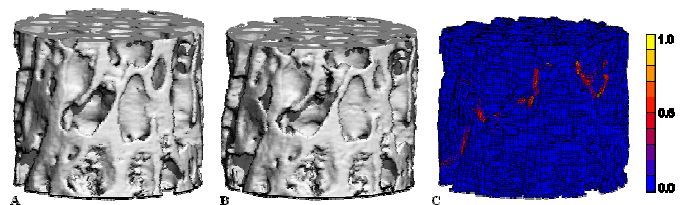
Rendered CT scans of sample 0 in its initial (A) and deformed (B) state. The deformed μ FE mesh (C) is shown for comparison. Local deformations in the CT scans compared well with deformations and high equivalent strain values in the μ FE models.
